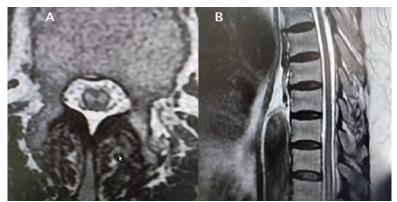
Spinal MRI showed increased intramedullary signal intensity at the T9 level in T2-weighted (A) axial, and (B) sagittal images
